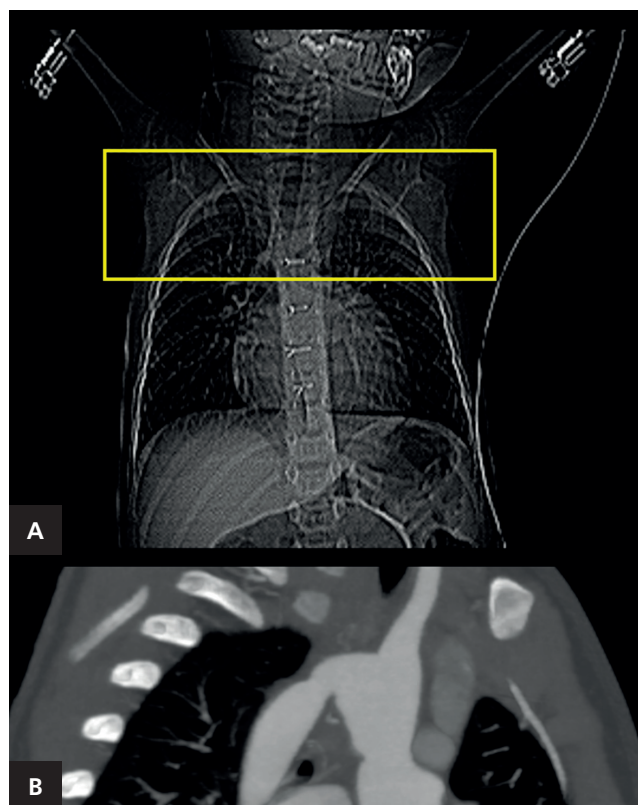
This figure depicts focused CT angiography. Part 1A shows the selection of the CT scanning range in a patient with recoarctation of the aorta. Part 1B presents a modified sagittal view, revealing the presence of recoarctation of the aorta within the predefined CT range.
